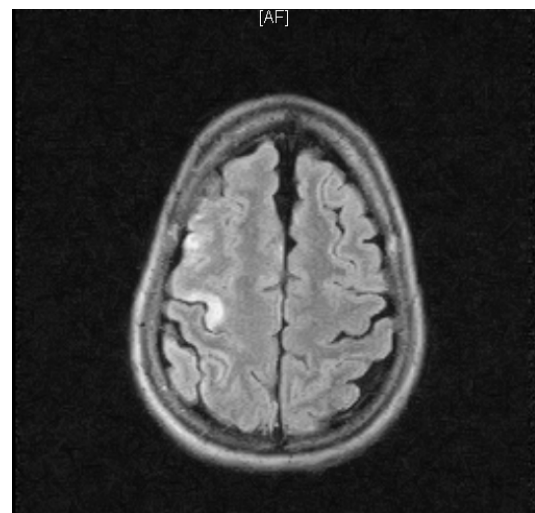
FLAIR magnetic resonance imaging (MRI) showing a well defined circumscribed acute infarction of the right precentral "hand motor cortex" area with the "omega sign"
